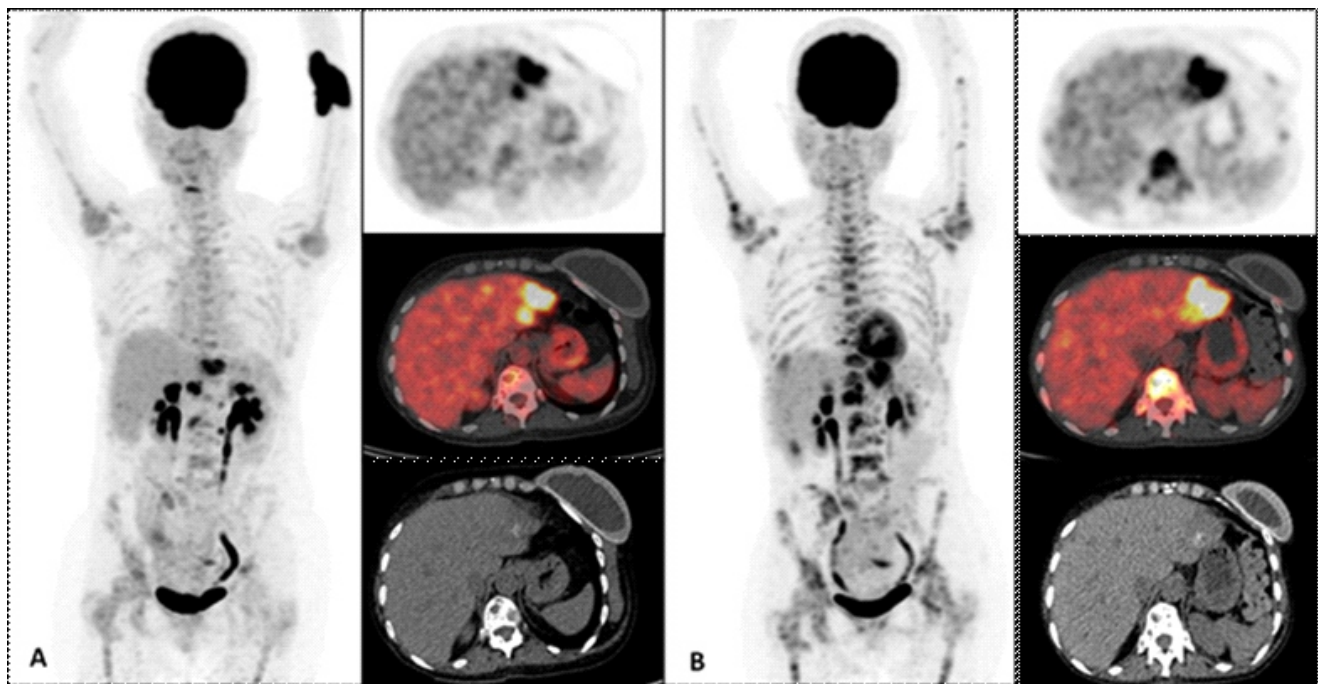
Maximum intensity projection and axial PET and fused PET/CT images of two ¹⁸F-FDG PET/CT scans, showing disease status prior to interrupt doxorubicin (A) followed by a clear progression after four months of therapeutic break (B) in a breast cancer patient.
